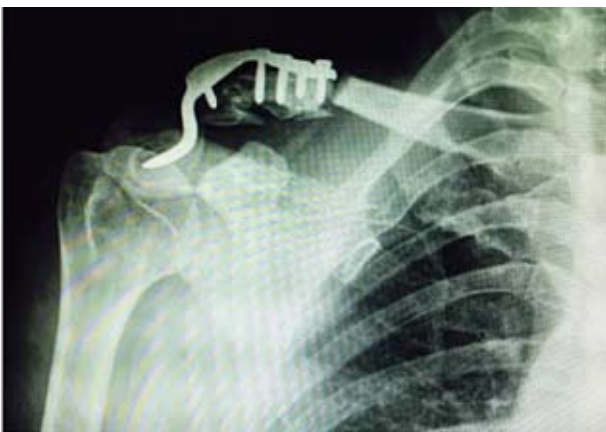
A radiograph demonstrating the clavicle fracture at medial end of the hook plate after the second injury.
